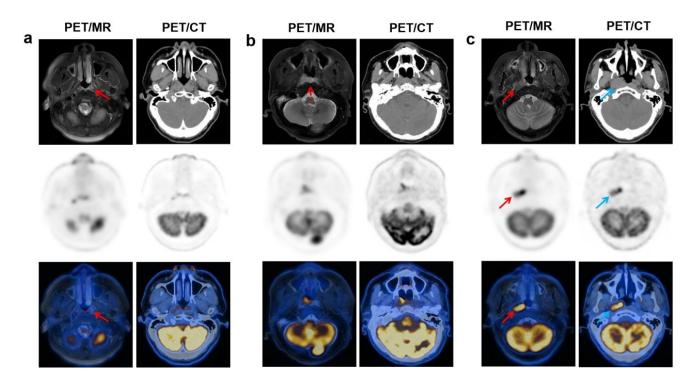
Detection of muscle extension. Each panel: top (MRIT2-fs or CT), middle (PET), and bottom (fused image). (a) The left tensor/levator veli palatine muscle was involved on PET/MR (red arrow), while was misjudged as normal on PET/CT (right column); (b) PET/MR was rated as negative for prevertebral muscle involvement as the mucosa line is intact (red dashed arrow), while was misjudged as positive on PET/CT (right column). (c) Medial pterygoid muscle was involved on PET/MR (red arrow), while cannot be distinguished on PET/CT and was rated as negative (blue arrow).
